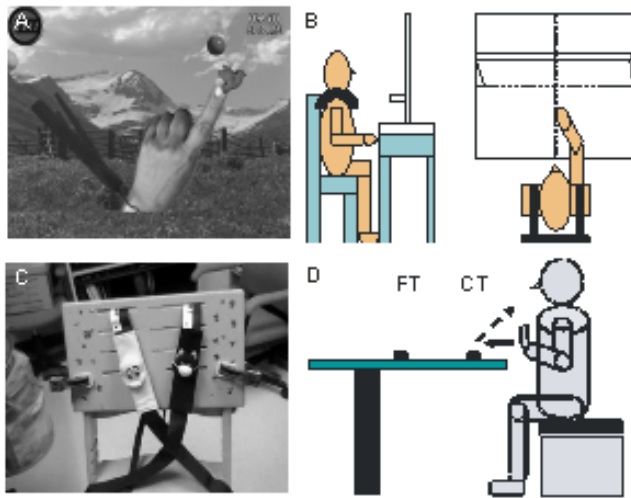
Upper limb motor training (A, B, C) and experimental (D) set-up for kinematic assessment. A. Example of a virtual game used during virtual training. B. Physical environment for reaching tasks. C. Trunk restraint system for upper limb training D. The assessment set-up with close and far target for reach-to-grasps tasks. CT: close target; FT : far target. Adapted with permission from *Dev Med Child Neurol*.
